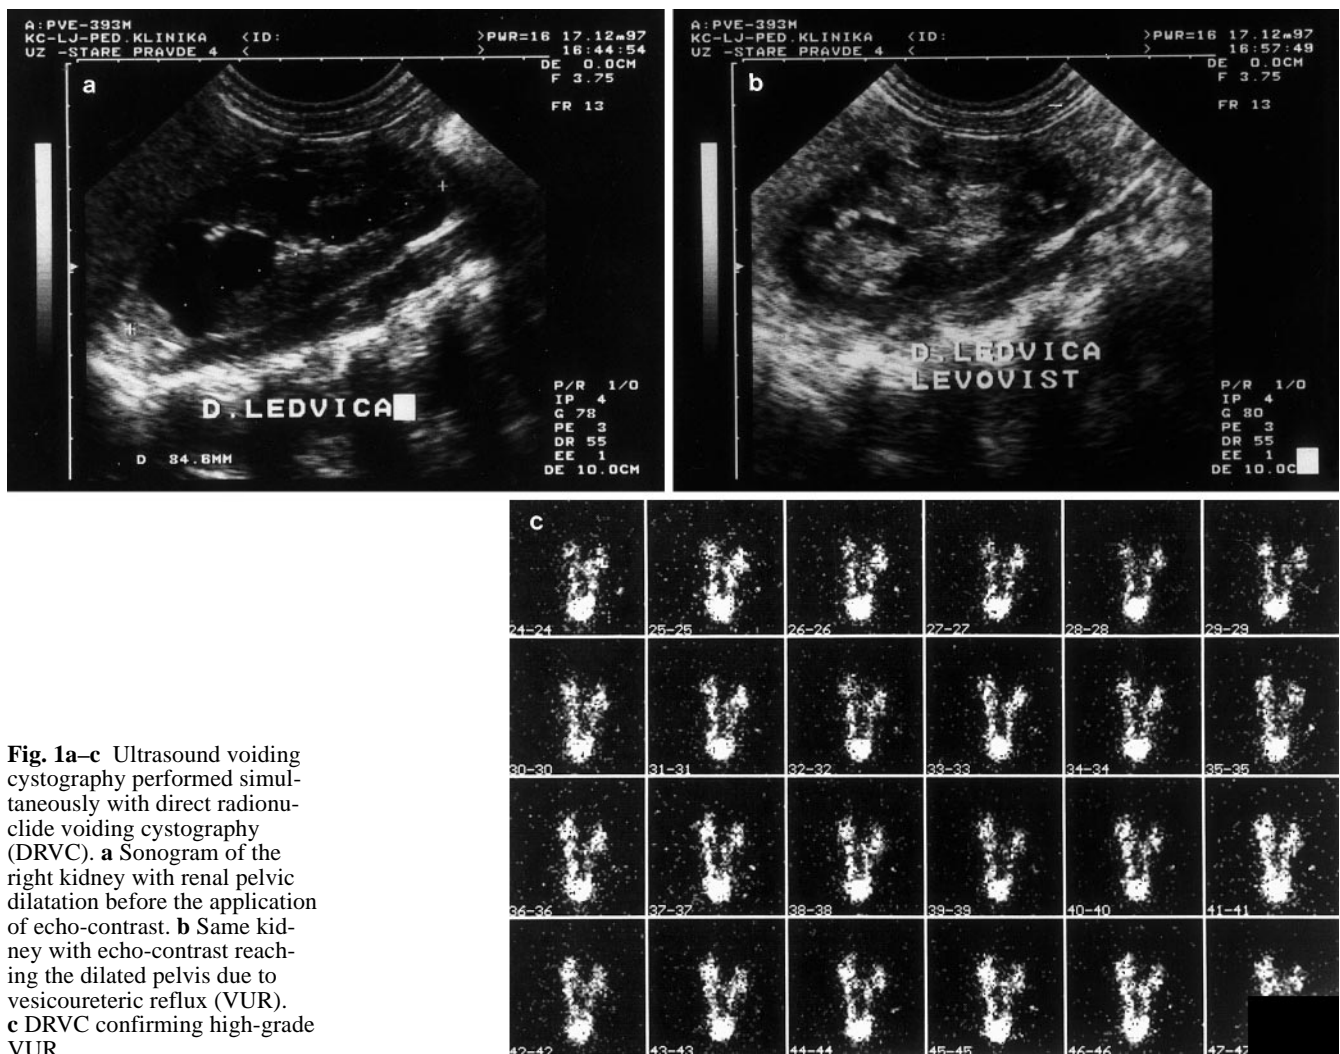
Ultrasound voiding cystography performed simultaneously with direct radionuclide voiding cystography (DRVC). a Sonogram of the right kidney with renal pelvic dilatation before the application of echo-contrast. b Same kidney with echo-contrast reaching the dilated pelvis due to vesicoureteric reflux (VUR). c DRVC confirming high-grade VUR
